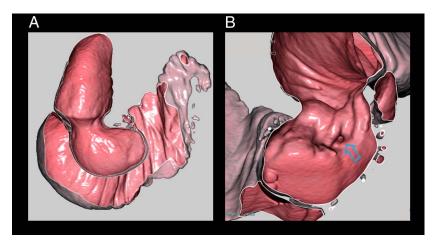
Computed tomography-duodenography images showing (A and B) the second portion of the duodenum is dilated and appears saccular: This proved to be the blind end of the duodenum. (B) A small orifice (arrow) is evident.
